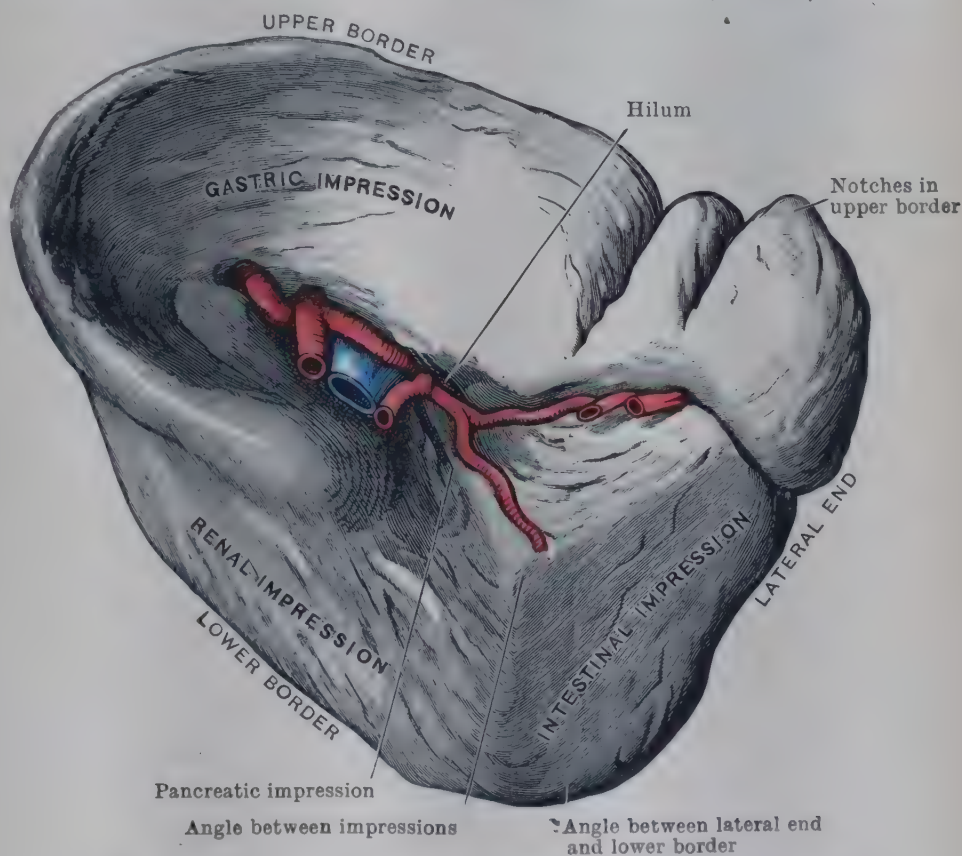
THE SPLEEN—VISCERAL ASPECT, TETRAHEDRAL FORM.
